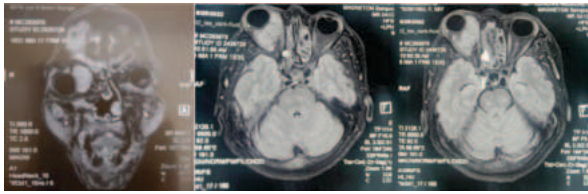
MRI orbit images of the patient showing right eye proptosis
